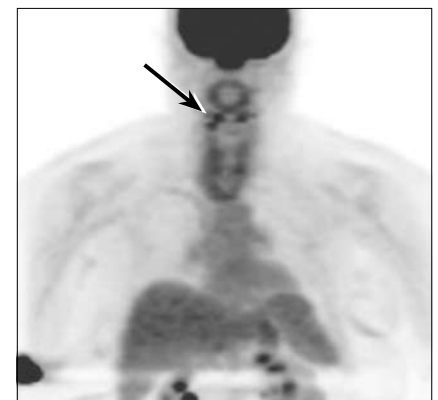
PET imaging from September 2009 demonstrates physiologic distribution of fluorodeoxyglucose (FDG) accumulation throughout the imaged body. Incidental note is made of partial dose infiltration at the right antecubital injection site. A tiny focus of increased FDG uptake was present in the right neck abutting the laryngeal cartilage but was not well visualized on the maximum-intensity projection (MIP) image.
